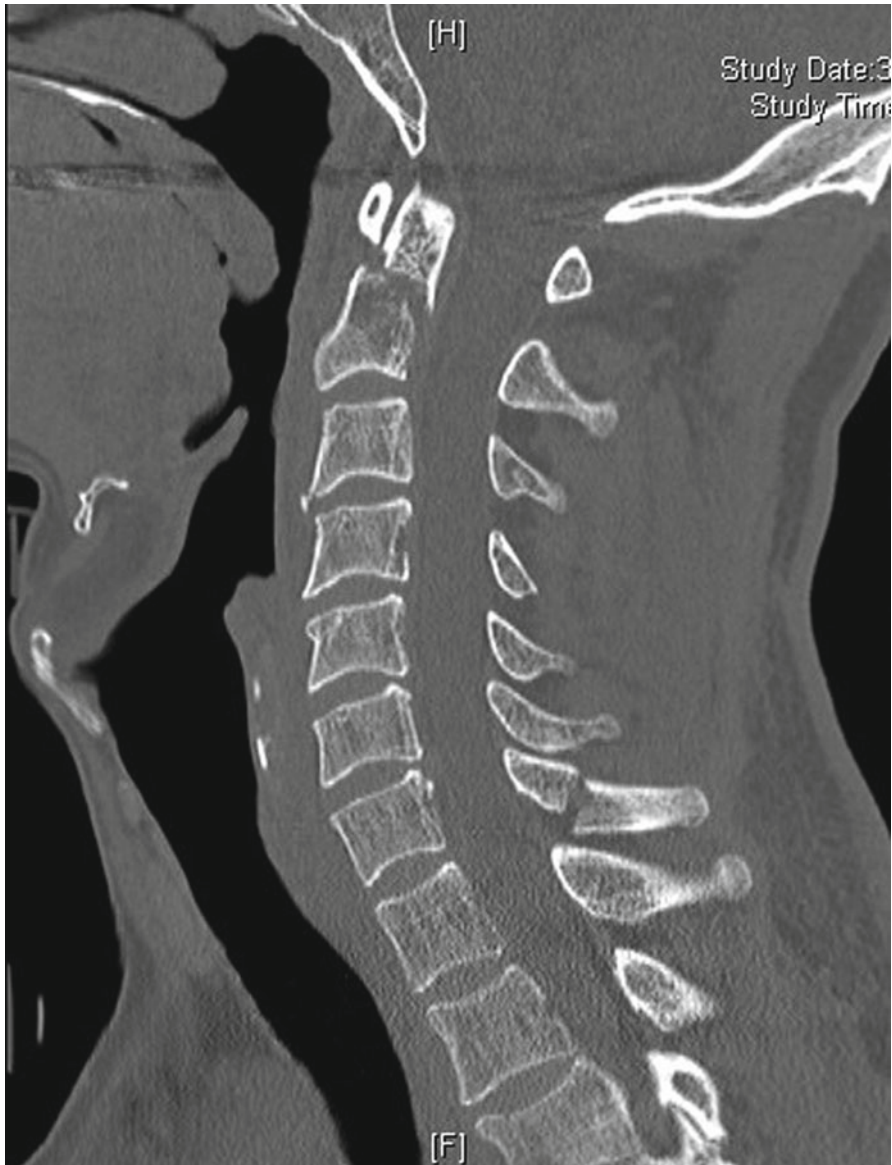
Sagittal CT section showing an Anderson and D'Alonzo type IIA odontoid fracture (Courtesy of Shibu P. Krishnan, London, UK)
